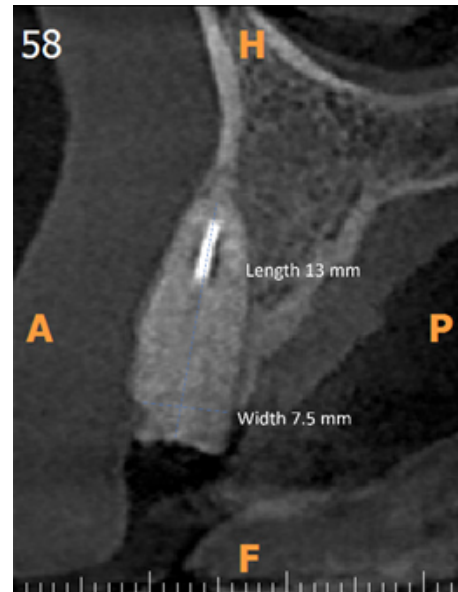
Pre operative radiograph of 13
